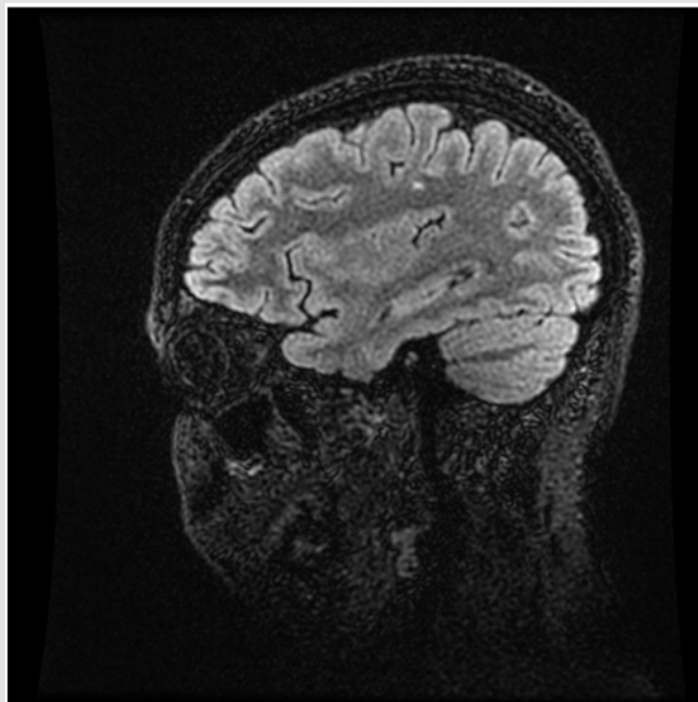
Axial MRI demonstrating periventricular white matter hyperintensities.
